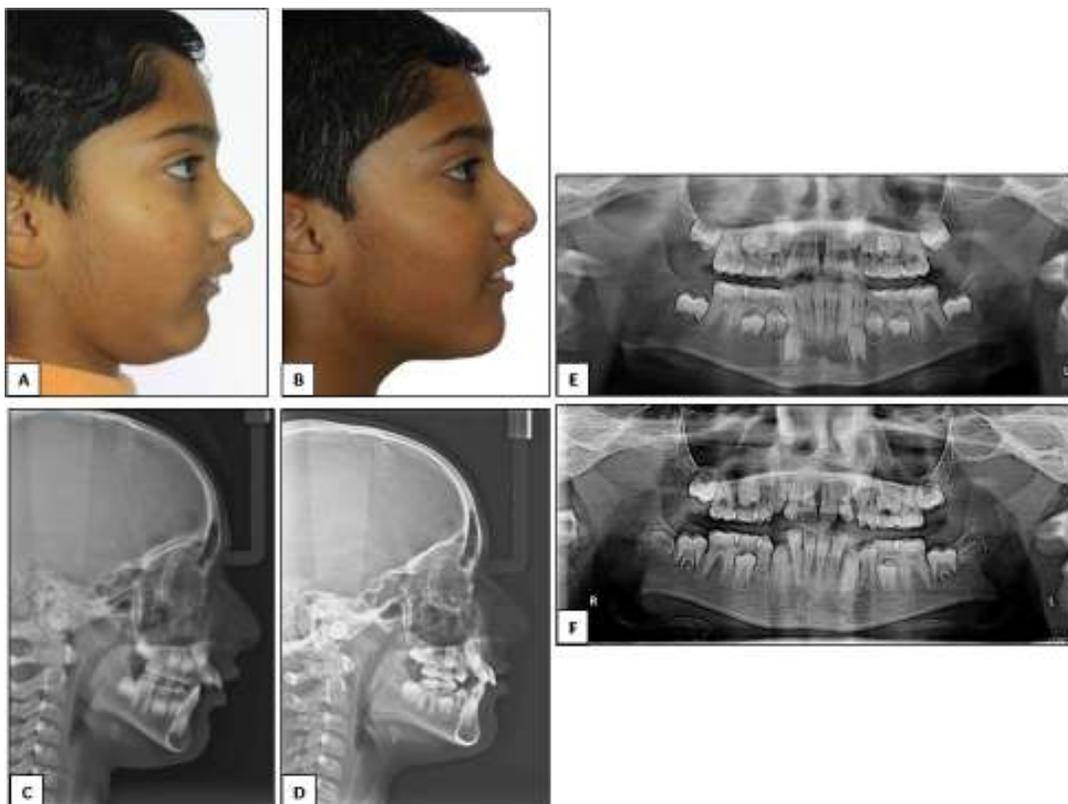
Change in profile, seen photographically and radiographically: (A) Extra-oral pre-functional profile photograph; (B) Extra-oral post-functional profile photograph; (C) Pre-functional lateral cephalogram; (D) Post-functional lateral cephalogram; (E) pre-functional OPG and (F) post-functional OPG
